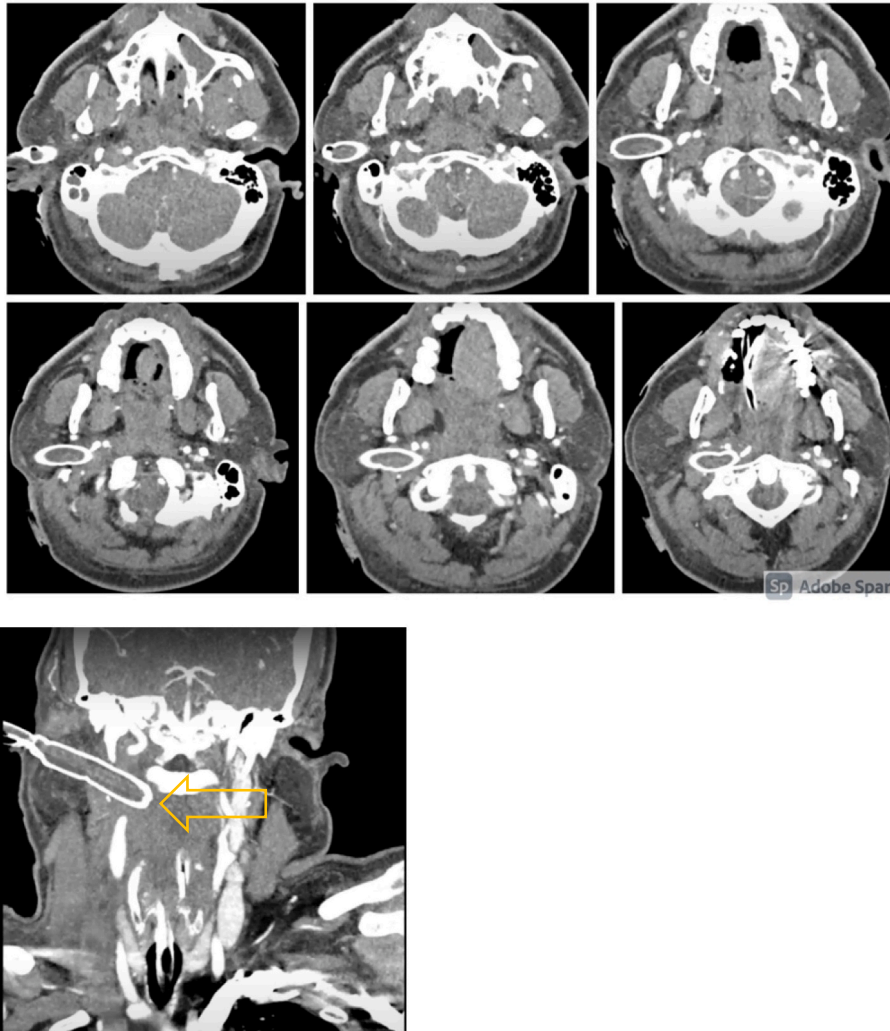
Neck CTA post operatively revealing tamponade of tract.
